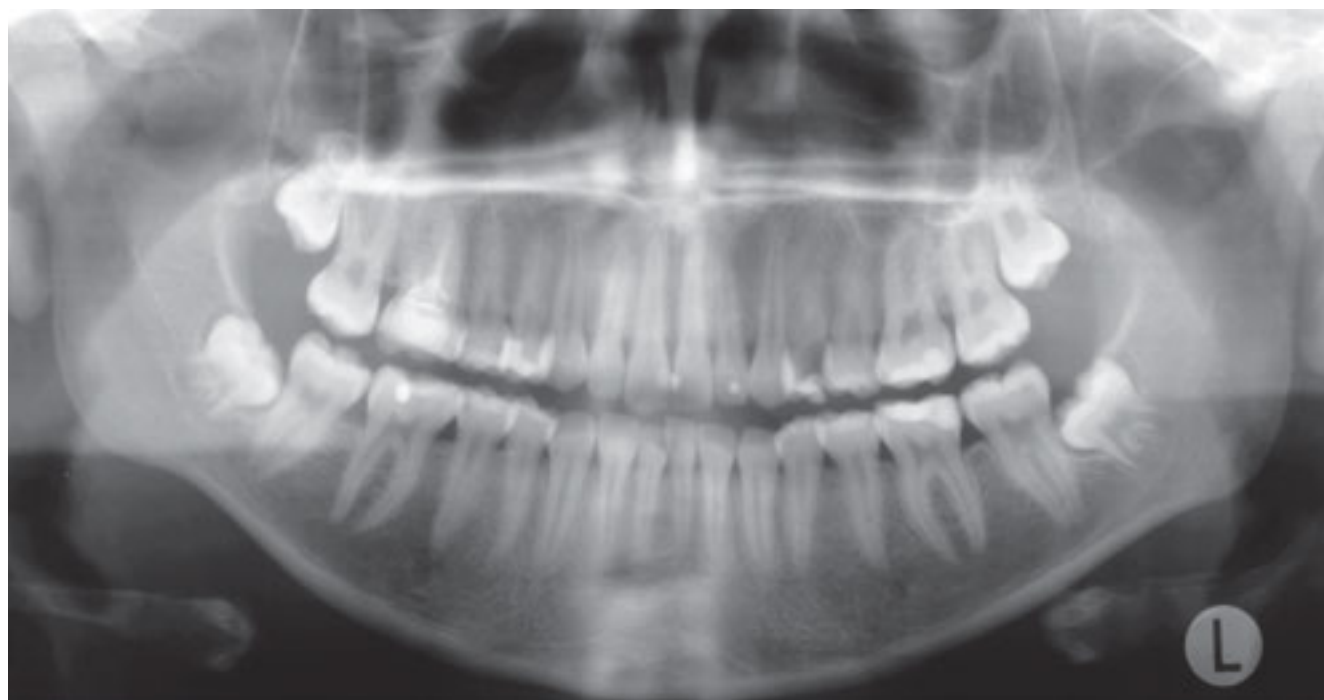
Preoperative panoramic radiograph of a 15 year old patient with insufficient root canal treatment and apical periodontitis tooth 16
